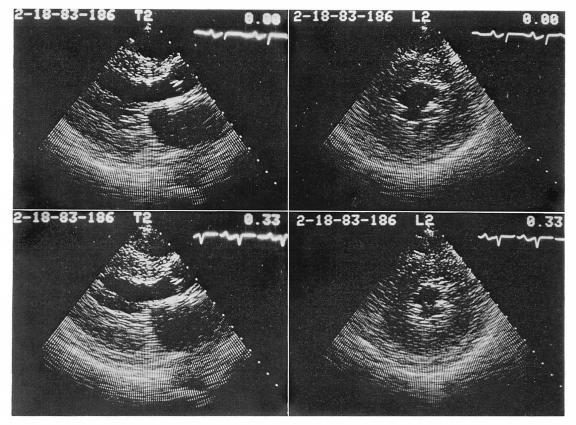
Two-dimensional echocardiograms obtained in a case with a hyperrefractile "granular sparkling" appearance of the thickened ventricular myocardium (Case 4).
